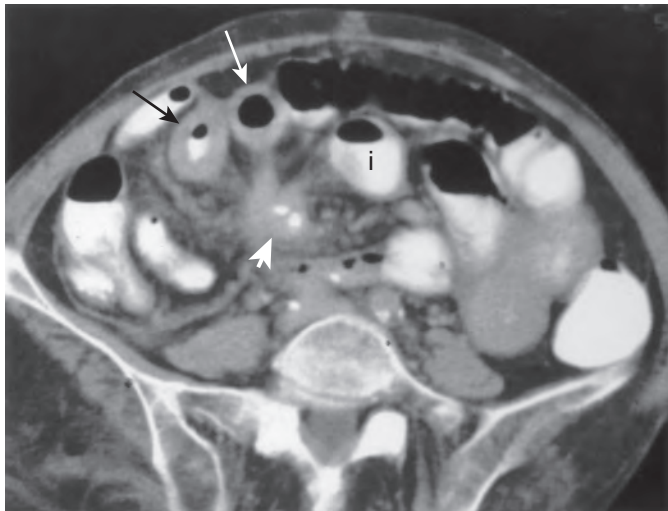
Carcinoid tumor causing partial obstruction and ischemia of the ileum. Axial CT scan through the pelvis demonstrates dilated ileum (i) but contrast in the colon, indicative of partial small bowel obstruction. A 2-cm centrally calcified mass (thick arrow) is seen in the root of the small bowel mesentery. Thick strands of tumor radiate from the ileum toward the mass. Two ileal loops (thin arrows) have uniformly thickened walls. At surgery, ischemic changes in the ileum were associated with the carcinoid tumor, which had spread to the root of the small bowel mesentery. (From Rubesin SE: Small bowel tumors. *Contemp Diagnost Radiol* 27:1-6, 2004.)
